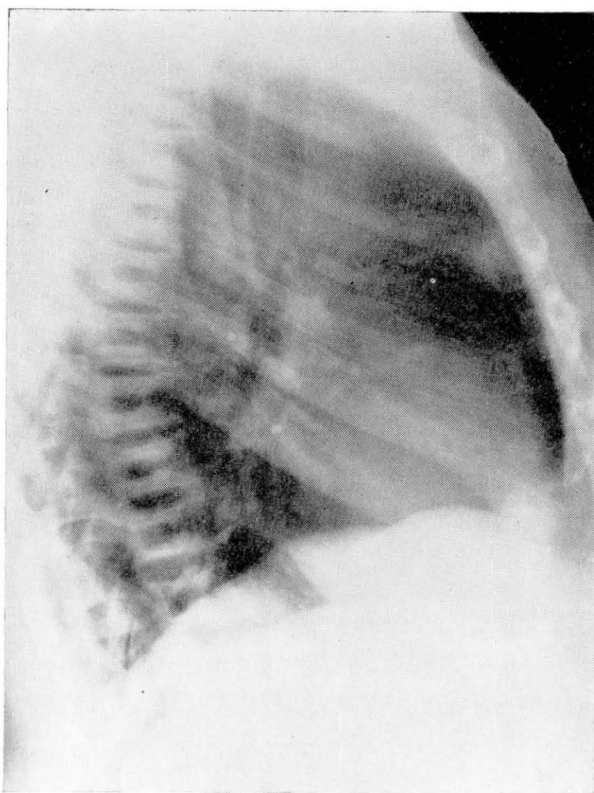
Lateral roentgenogram of the thoracic vertebrae showing the typical sawdust-like appearance.
